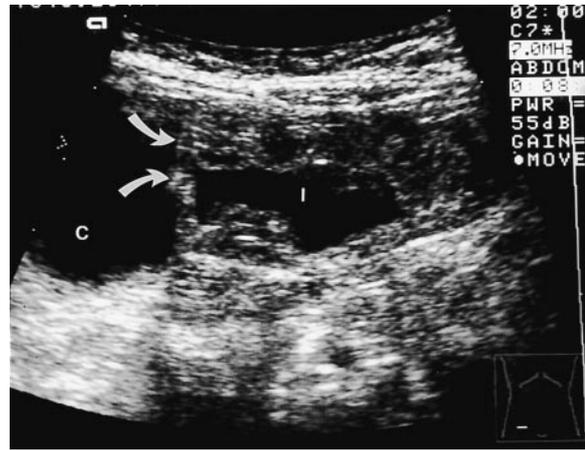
Ultrasound of the right iliac fossa following successful ultrasound-guided hydrostatic reduction of intussusception. Hartmann's solution is present in the caecum (C) and terminal ileum (I). The oedematous lips of the ileocaecal valve are arrowed.
